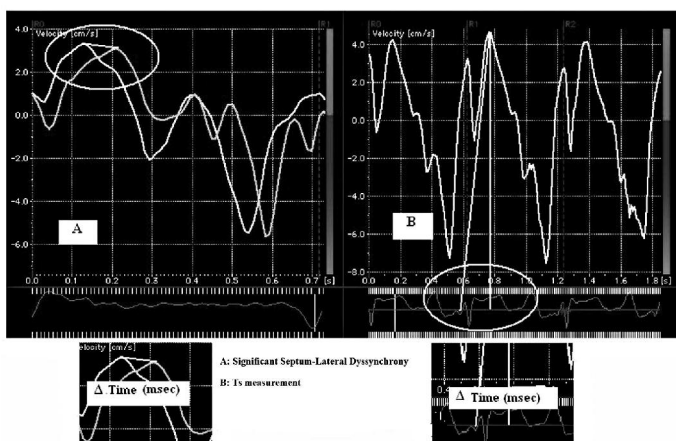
Tissue Doppler derived myocardial velocity curves demonstrating significant septum-lateral systolic dyssynchrony and Ts measurement.
